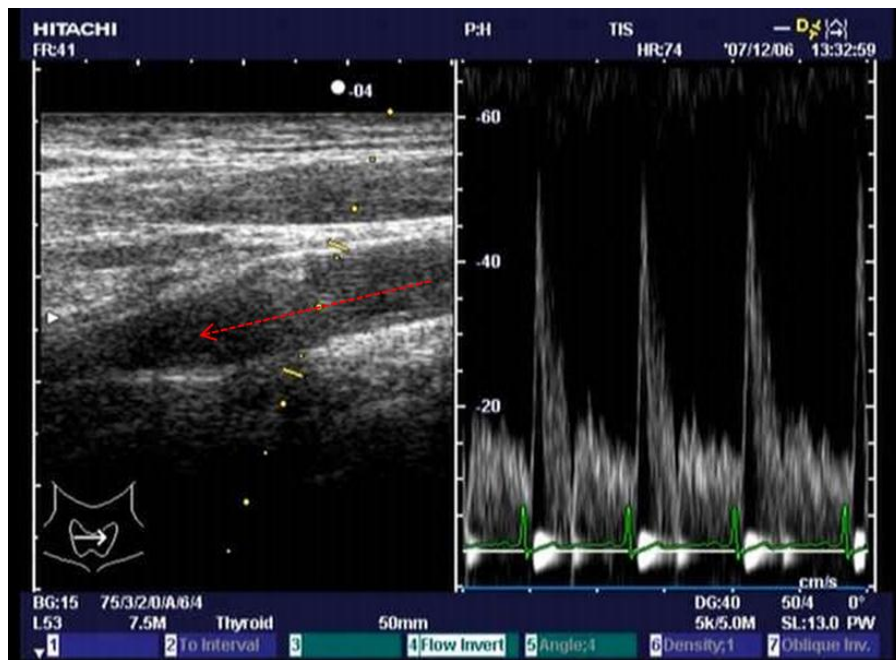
Screenshot of a Doppler spectrum. Note that the angle between the ultrasound beam (yellow dashed line) and the approximate blood flow direction (red dashed arrow) is about 60 degrees. Given the measured PSV of 55 cm/s from the spectrum, the angle corrected PSV is 110 cm/s in this case.
